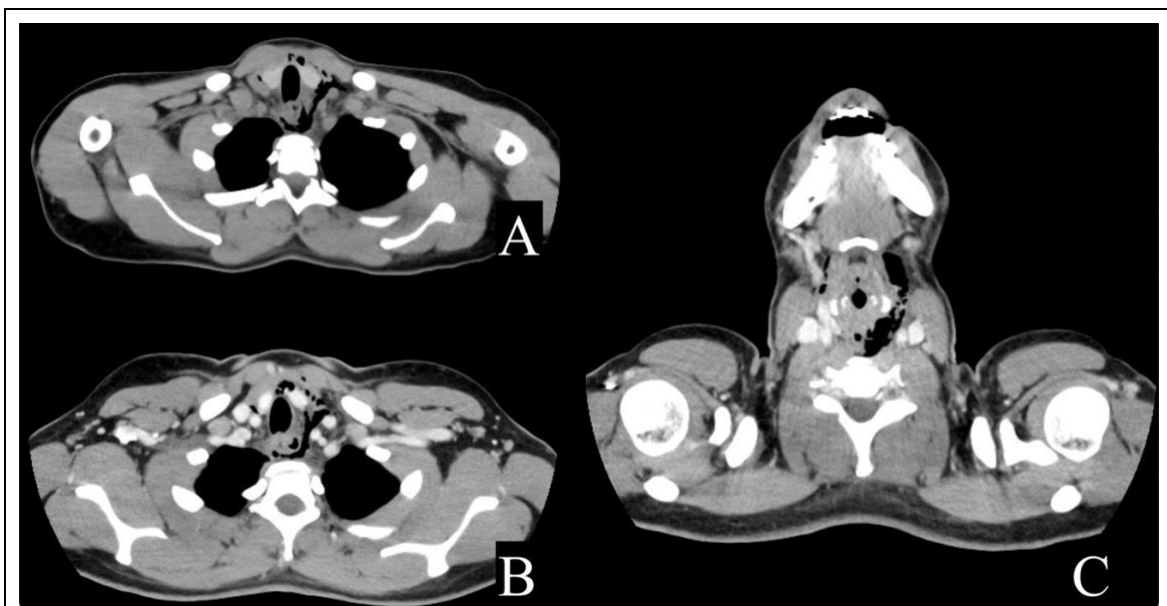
A plain computed tomography revealed gas in the nasopharynx, temporomandibular joint, pharynx, larynx, and tracheal bifurcation area (A), however, no enhancement around the emphysema (B,C).
